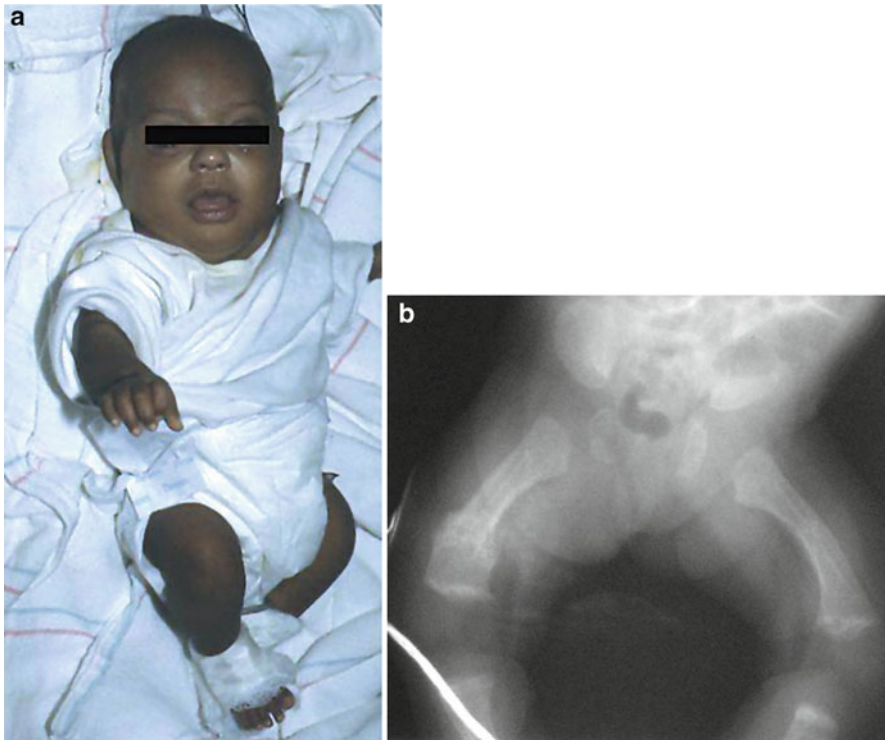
(a, b) An infant with healing nutritional rickets (a). The radiograph (b) shows femoral bowing and a healing fracture with callus formation in the right femur
